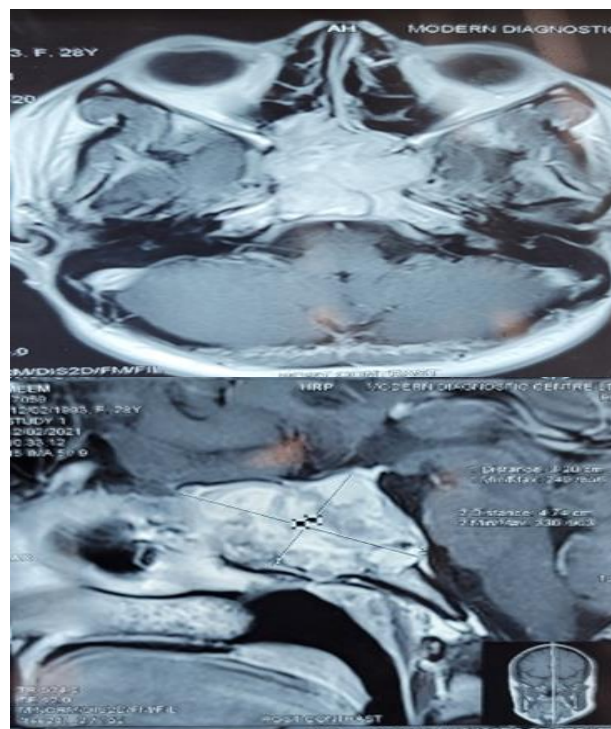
(MRI) of brain which showed there was a large lobulated strongly enhancing lesion measuring about 4.1×2.4×2.5 cm; in basi-sphenoid area, extending anteriorly and compressing the optic chiasma and optic tract with both parasellar extension and inferiorly deepening into sphenoid sinus.
